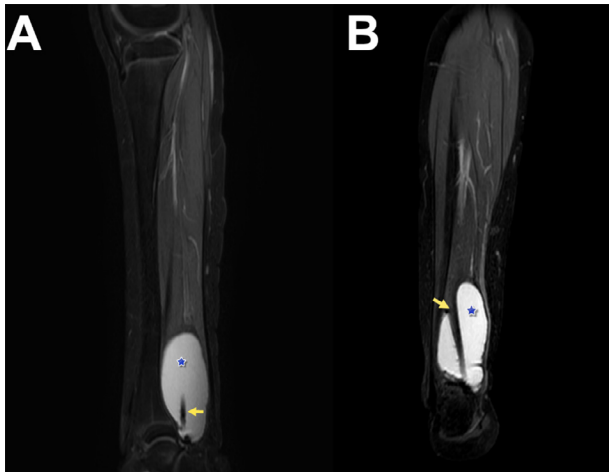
Sagittal (A) coronal T2 fat-saturation and (B) magnetic resonance imaging cuts demonstrating an ovoid T2 hyperintense cystic lesion (blue star) with the flexor hallucis longus coursing through the cystic area (yellow arrow).
